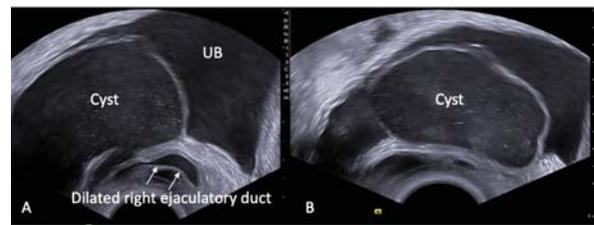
Transrectal sonography (TRUS) images showing dilated right ejaculatory duct communicating with dilated right seminal vesicle protruding into the urinary bladder (A); Rather than purely anechoic, there are innumerable punctate echogenic dots/ low level internal echoes seen within the cyst (B).
